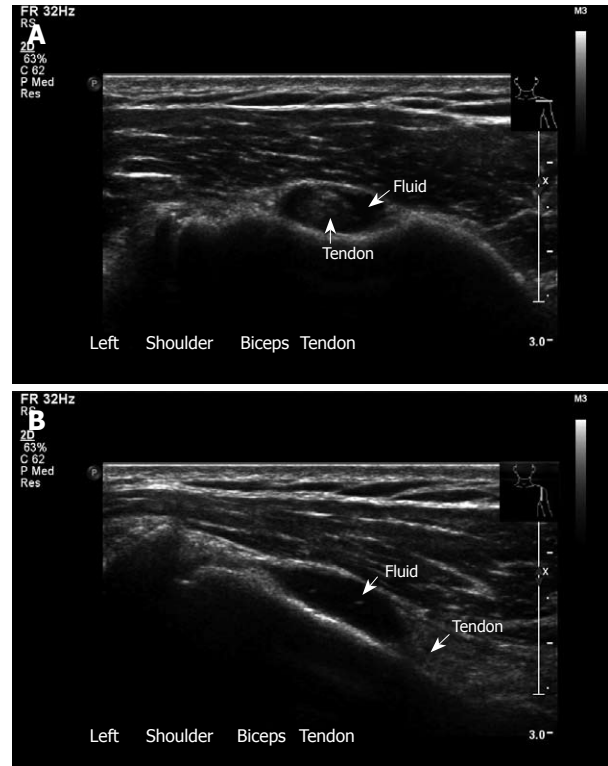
Biceps tendon. A: Bicipital tendinitis. Transverse sonogram. The tendon is surrounded by fluid. This 33-year old woman presents with pain and local tenderness in the area of the bicipital groove; B: Longitudinal view with fluid around the biceps.
